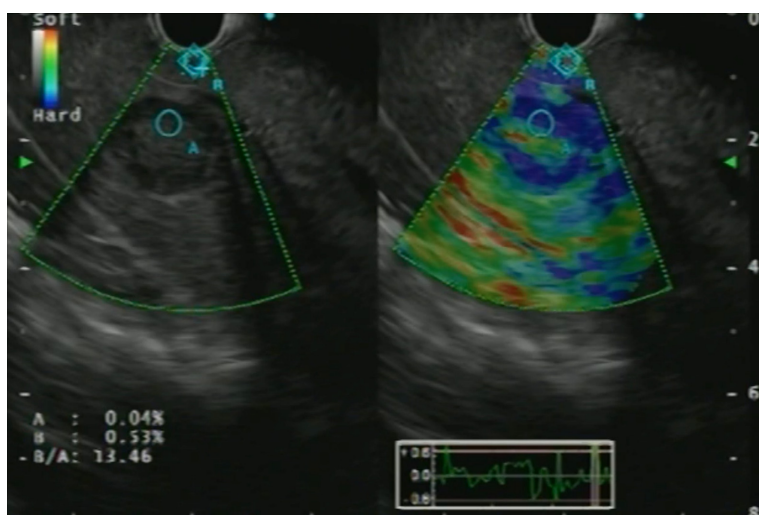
Endoscopic ultrasound elastography of a focal liver lesion with strain ratio calculation.
